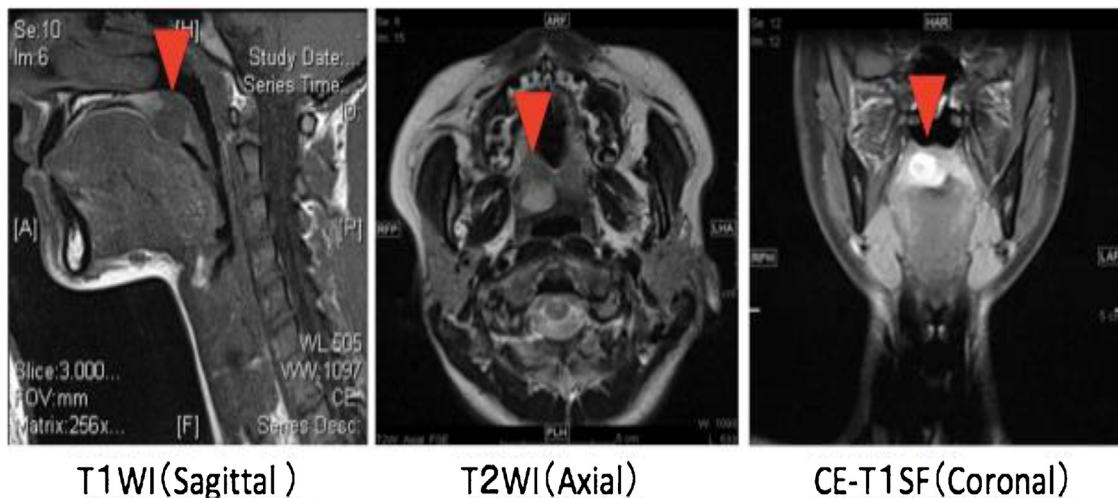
Magnetic resonance imaging Schwannoma (▼).
